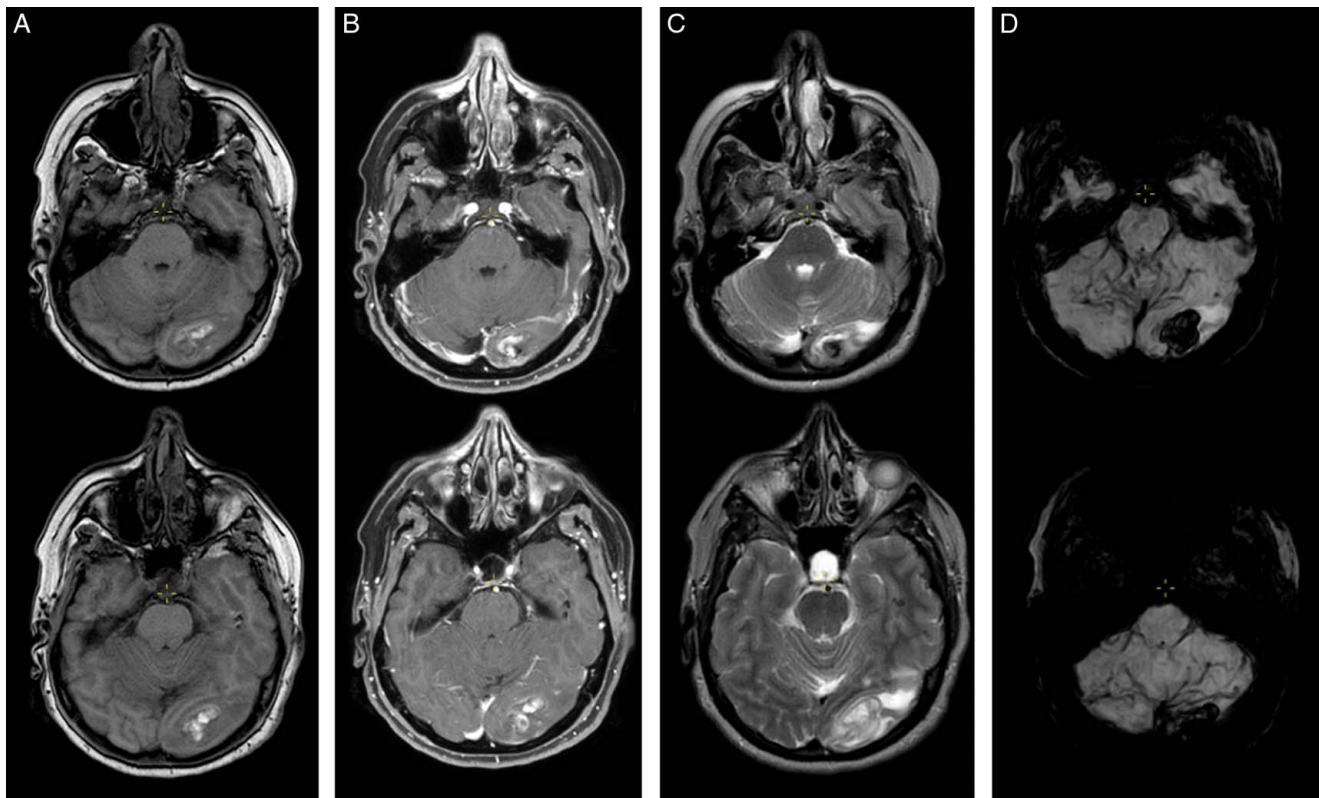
Axial T1-weighted images before (A) and after (B) intravenous contrast administration demonstrate a relatively well-defined left occipital lesion, showing slightly heterogeneous mainly high signal with a halo and foci of low signal, revealing subtle eccentric peripheral enhancement. On T2-weighted images (C), the lesion appears heterogeneous of both high and foci of low signals surrounded by vasogenic edema. The lesion shows blooming artifact on susceptibility-weighted images (D).
